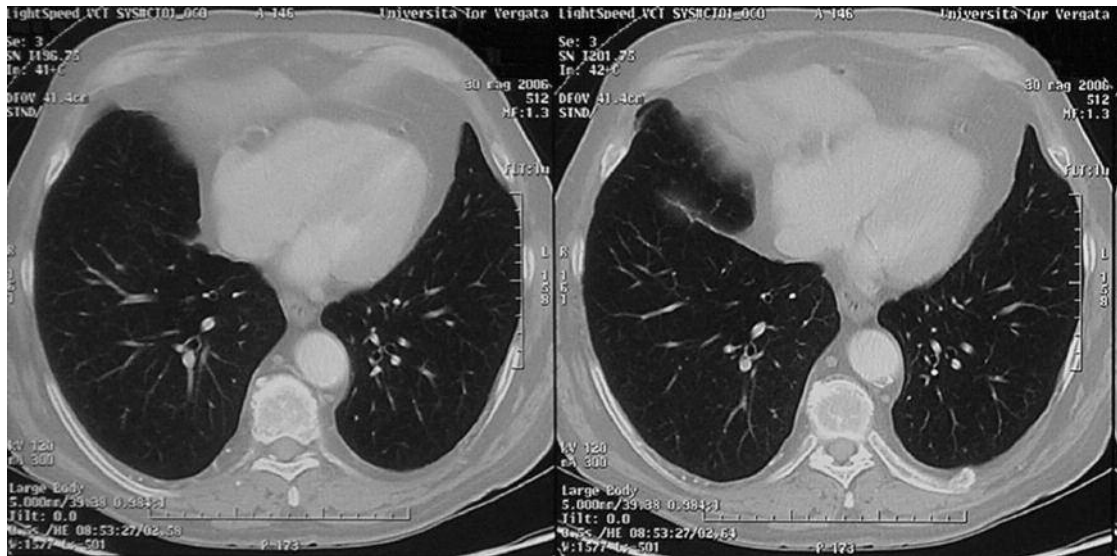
Restaging CT scan after 4 cycles of combined gemcitabine/vinorelbine plus inhaled IL-2 treatment showing a complete remission of lung metastases.
